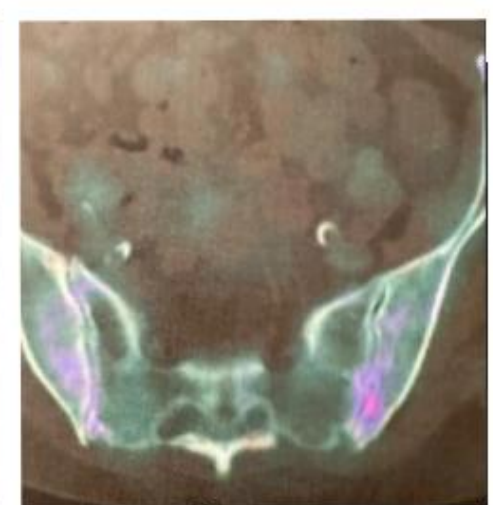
Axial fused SPECT-TC demonstrate increased radiotracer uptake at bilateral sacroiliac joint, concerning for sacroiliac degenerative arthropathy.
